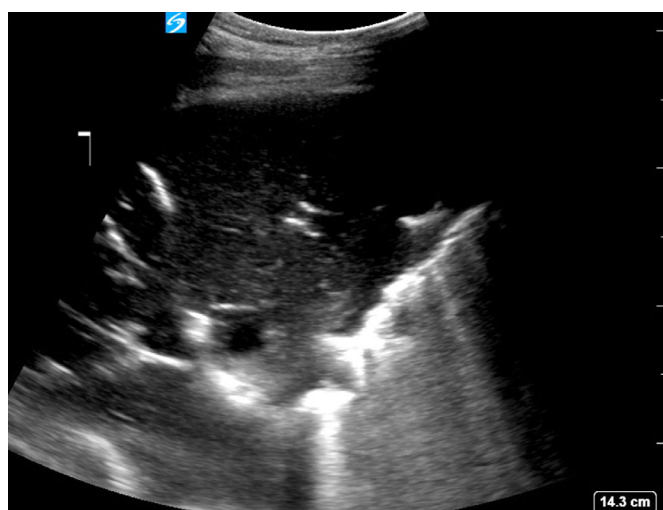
Lobar consolidation as seen with a curved probe. The uneven hyperechoic white margin on the lower right of screen is aerated lung abutting the consolidation. Use colour Doppler to look for hyperaemia or relative ischaemia. [Colour figure can be viewed at wileyonlinelibrary.com]
